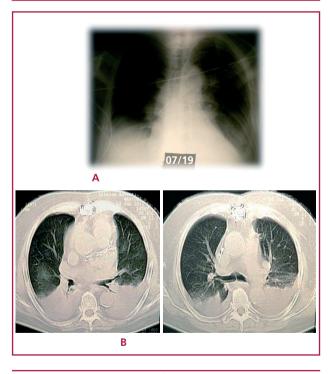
A. Chest x-ray 1 week after corticosteroid therapy. B. Computed tomography scan one week after corticosteroid therapy.
